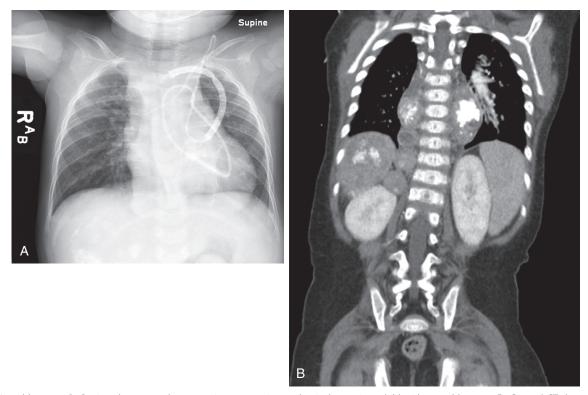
Neuroblastoma. A, Supine chest x-ray demonstrating a posterior mediastinal mass in a child with neuroblastoma. B, Coronal CT demonstrating extent of paraspinal masses in a child with newly diagnosed neuroblastoma.
